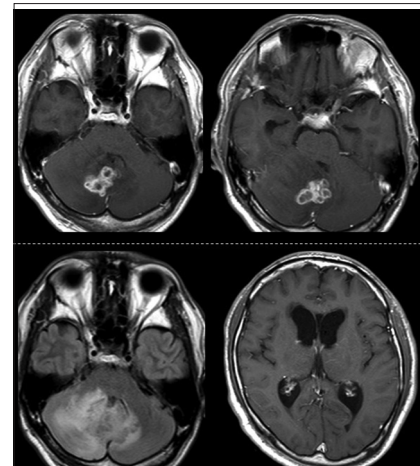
Magnetic resonance images showed a nodular lesion with ring enhancement by gadolinium contrast medium in the cerebellar hemisphere extending to the vermis, compressing fourth ventricle (upper 2 slides). The lesion was associated with perifocal edema and bilateral ventriculomegaly (lower 2 slides).
